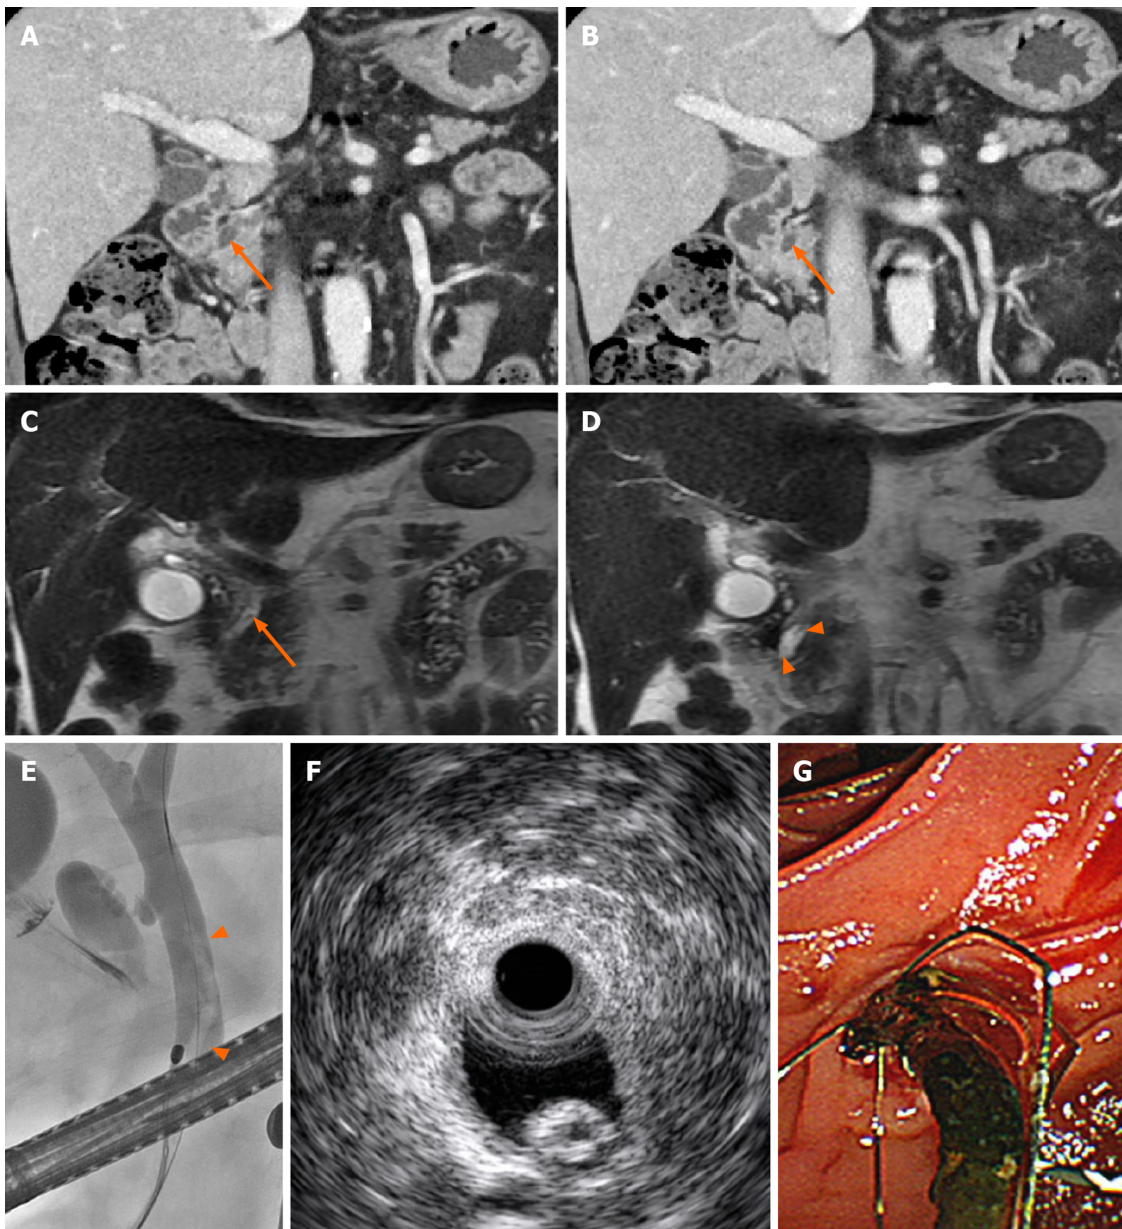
A 72-year-old male with a distal common bile duct stone mimicking *Ascaris*. A and B: Coronal reformatted images of contrast-enhanced computed tomography showed a hyperattenuated, elongated lesion inside the distal common bile duct (CBD) lumen (arrows); C and D: A T2-weighted coronal image revealed a linear filling defect in the distal CBD lumen with mild ductal dilatation, findings that mimic an *Ascaris* worm; E and F: An elongated tubular filling defect was seen on endoscopic retrograde cholangiopancreatography, and a hyperechoic lesion with a central hypoechoic area was seen on endoscopic ultrasound; G: A dark-brown-colored CBD stone was discovered through endoscopic removal.
